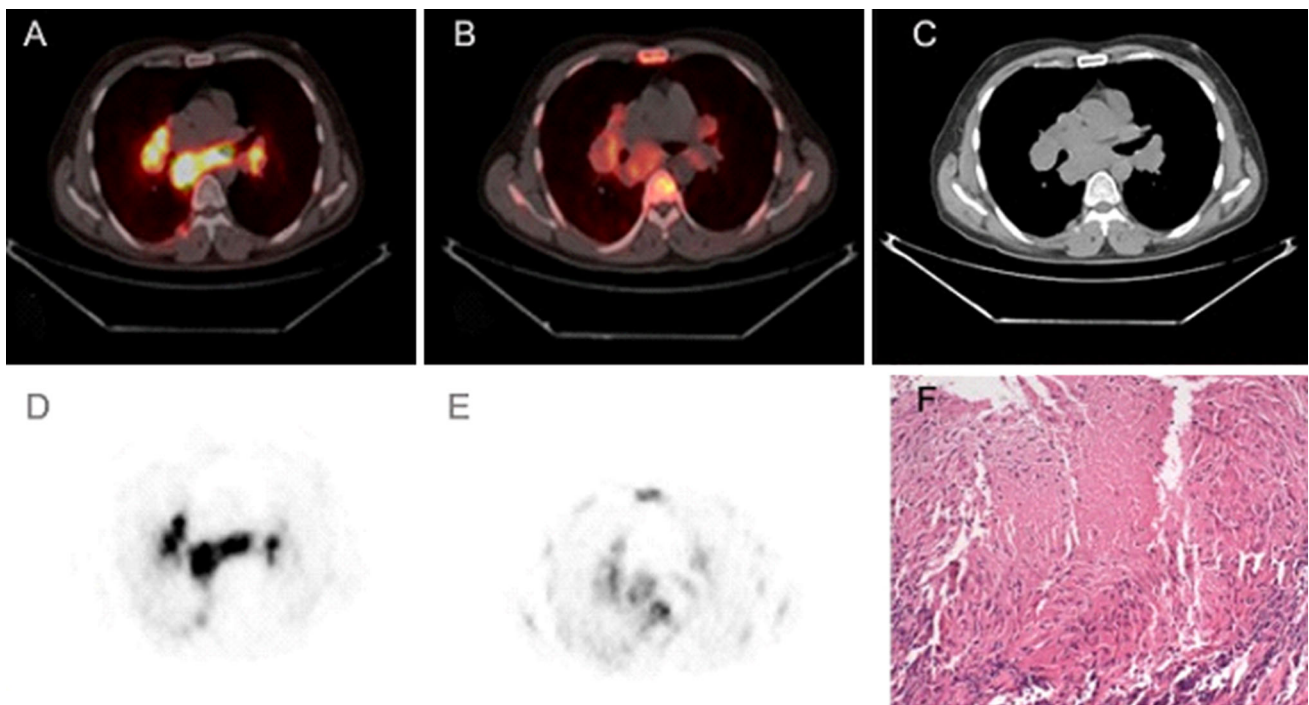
Transaxial fused ^{18}F -FDG PET/CT (a) and ^{18}F -FLT PET/CT (b), CT only (c), FDG PET (d) and FLT PET (e) showing increased tracer uptake in subcarinal and bilateral hilar lymph nodes in a
